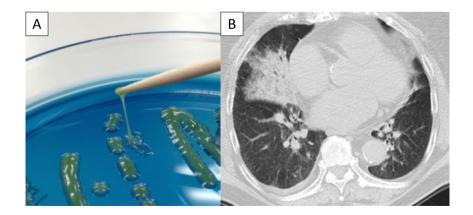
String test and chest computed tomography for identification of hypermucoviscosity-phenotype *Klebsiella pneumoniae*. A positive finding of the string test is defined as the formation of viscous strings of >5 mm in length on an agar plate (A). Consolidation of right middle lobe caused by hypermucoviscosity-phenotype *K. pneumoniae* was seen in Case 1 (B).
